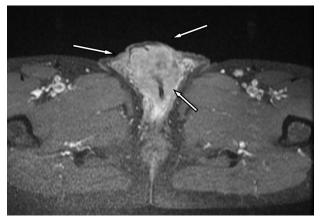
Contrast enhanced MRI showing moderate heterogeneous enhancement of mass
